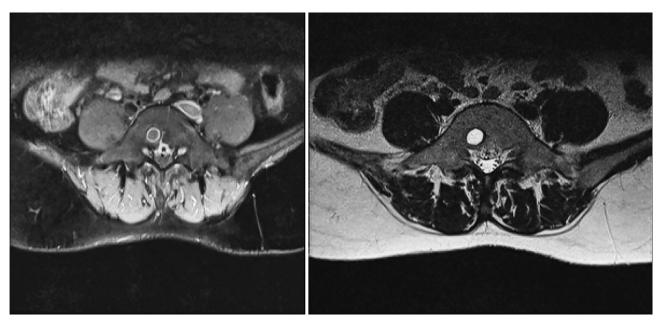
Axial T2\*-weighted MR image of the fifth lumbar vertebra shows homogeneous and hyperintense appearance of the lesion. Axial T1-weighted with contrast show minimal peripheral enhancement.
